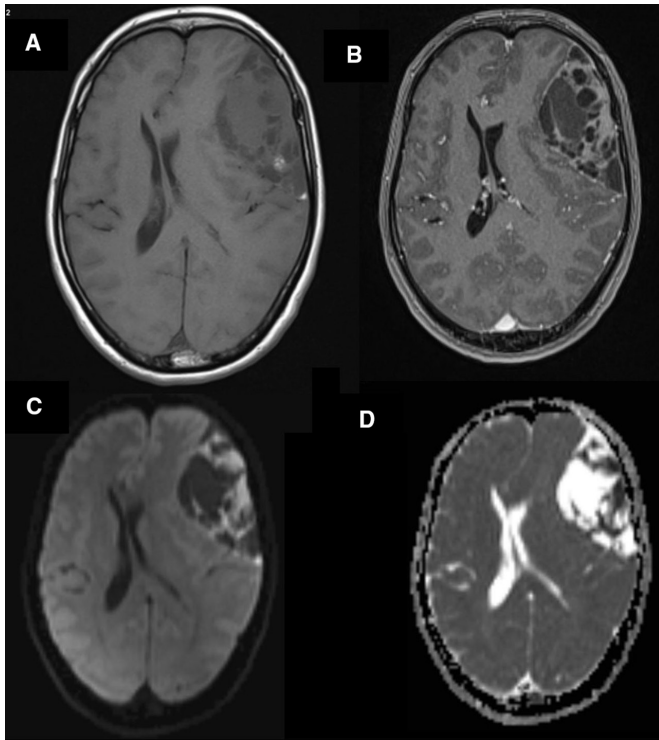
(A) The axial T1 weighted imaging (T1WI) depicts a heterogeneously hypointense multicystic lesion in the left frontoparietal convexity. Few areas of T1 hyperintensity suggestive of subacute haemorrhage are noted within the mass. (B) The axial postgadolinium injection T1 fat-suppressed image shows enhancement of the septations and tumour periphery. Small enhancing dural tail is also noted. (C) Axial diffusion-weighted imaging (DWI) image shows restriction in the thick septations of the left extra-axial mass. (D) Apparent diffusion coefficient image shows the corresponding hypointense signal in the areas of hyperintensity in DWI.
